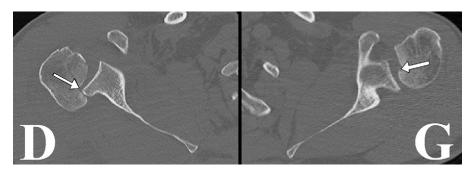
Preoperative computed tomography of both shoulders. Anterior impression defects (McLaughlin fracture or reverse Hill-Sachs lesion) are visible on both humeral heads. The percentage size of the humeral impression fracture is 30% for the left side and 60% for the right side.
